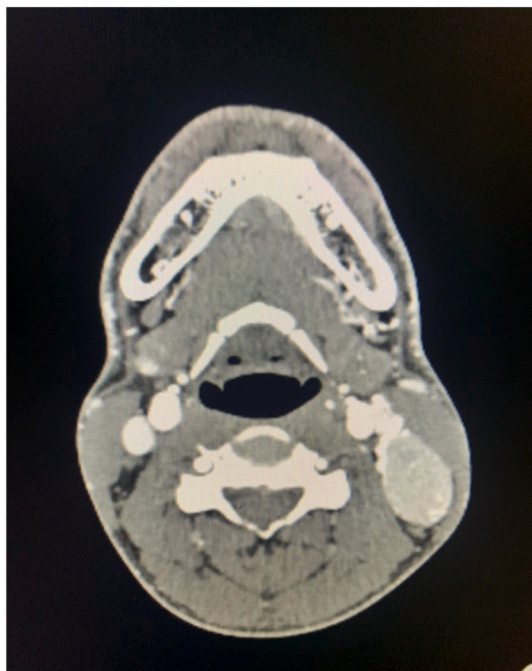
Contrast-enhance axial CT scan demonstrates hyperdense enhancing mass.
